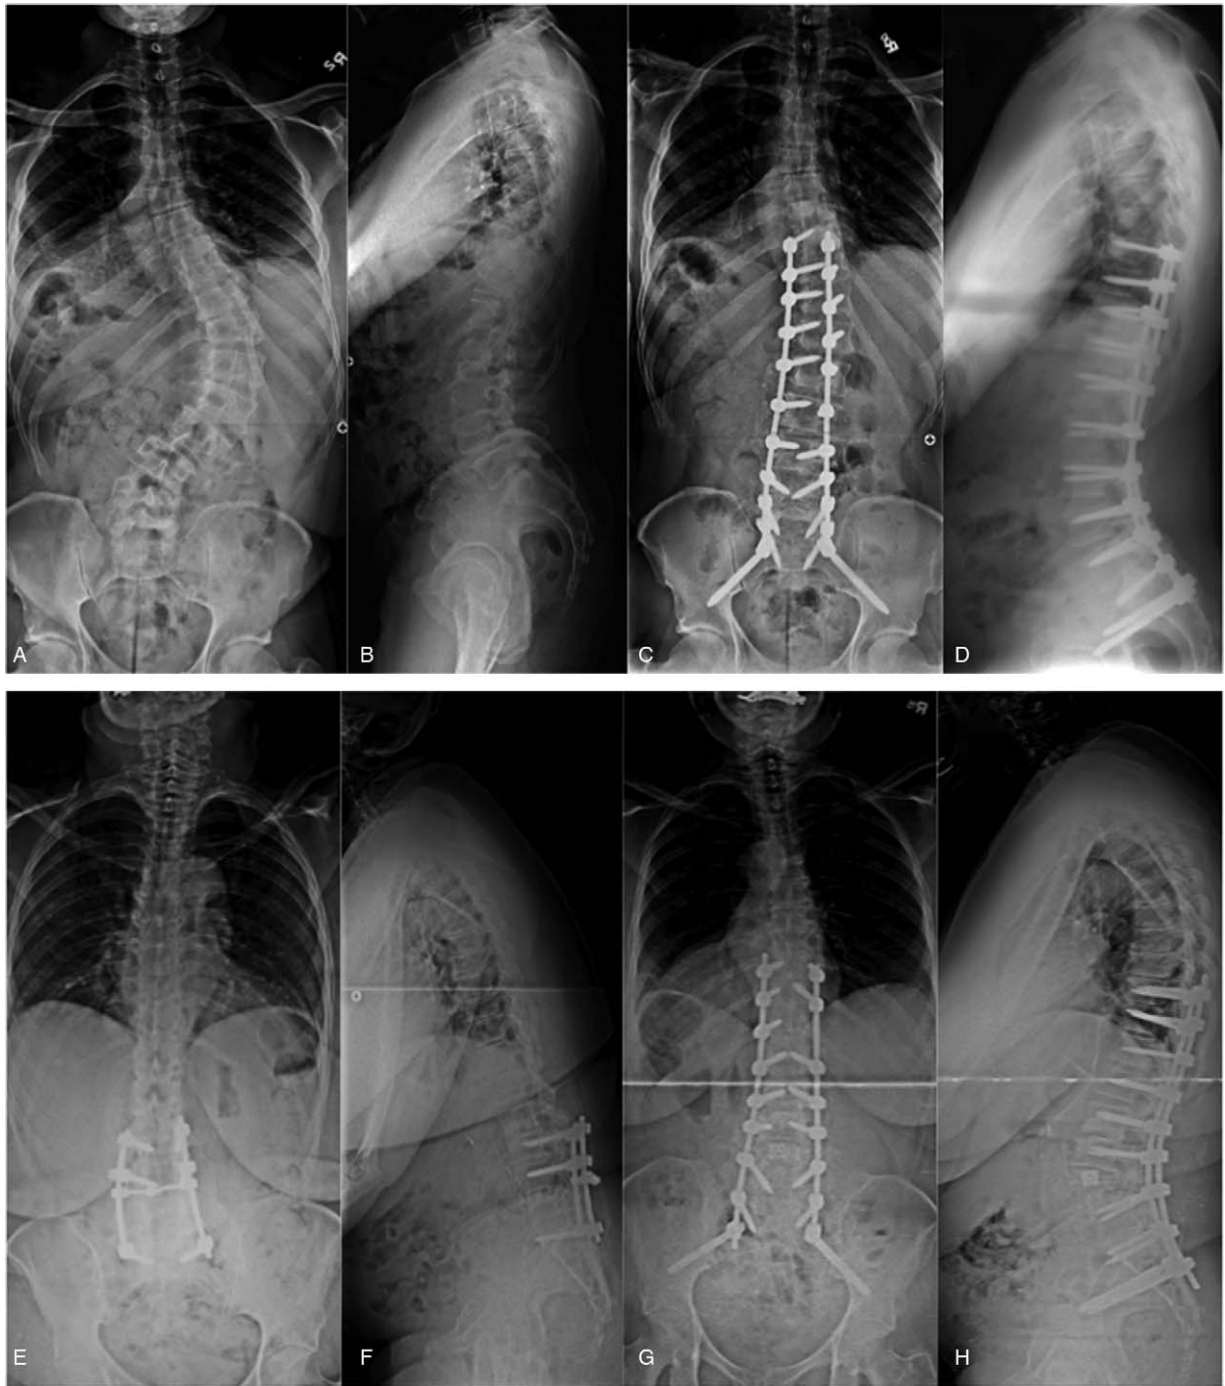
Radiographs of two patients who underwent adult spinal deformity procedures that were below and above the Adult Spinal Deformity Surgical and Radiographic (ASD-SR) cutoff score of 90 points, respectively. Preoperative anteroposterior (A) and lateral (B) and postoperative anteroposterior (C) and lateral (D) radiographs of a patient whose procedure had an ASD-SR score of 63. This patient underwent primary arthrodesis from T9 to the pelvis (30 points) with 6 Smith-Petersen osteotomies (6 points) and two levels of decompression (2 points), iliac fixation (2 points), and anterior lumbar interbody fusion (ALIF) (8 points). Treatment resulted in a 1.1-cm increase in sagittal vertical axis (0.2 points), a 9° decrease in thoracic kyphosis (4.5 points), a 2° decrease in pelvic incidence minus lumbar lordosis, and a 4.7° increase in pelvic tilt (9.14 points). The patient had no major postoperative complications. Preoperative anteroposterior (E) and lateral (F) and postoperative anteroposterior (G) and lateral (H) radiographs of a patient whose procedure had an ASD-SR score of 103. This patient underwent revision arthrodesis (3 points) from T10 to the pelvis (27 points), involving a 3-column osteotomy (14 points), iliac fixation (2 points), and ALIF (8 points). Treatment resulted in a 13-cm decrease in sagittal vertical axis (2.6 points), a 35° increase in thoracic kyphosis (17.5 points), a 31° decrease in pelvic incidence minus lumbar lordosis (15.5 points), and a 6.6° decrease in pelvic tilt (13.2 points). The patient had a major complication (pulmonary embolism) on postoperative day 4, which was treated appropriately and eventually resolved.
